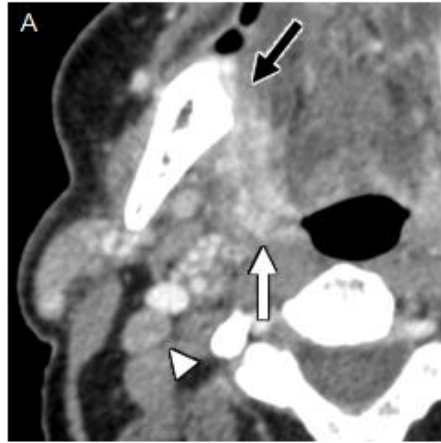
65-year-old man with moderately to poorly differentiated nonkeratinizing squamous cell carcinoma of the left nasopharynx (HPV related). Axial CECT (A) shows a left nasopharyngeal mass (white arrow) with abnormal soft tissue thickening extending posterolaterally (white arrowhead). Pretreatment axial 18F-FDG PET/CT shows corresponding FDG avidity in the pharyngeal recess of the left nasopharynx (black arrow), as well as FDG avid tumor extending posteromedial toward the left carotid space (black arrowhead). 6-month post-treatment axial 18F-FDG PET/CT (C) shows no significant FDG uptake at the primary mucosal site (black arrow), as well as no significant FDG uptake corresponding to persistent mild left lateral retropharyngeal soft tissue (black arrowhead), consistent with treated disease.
